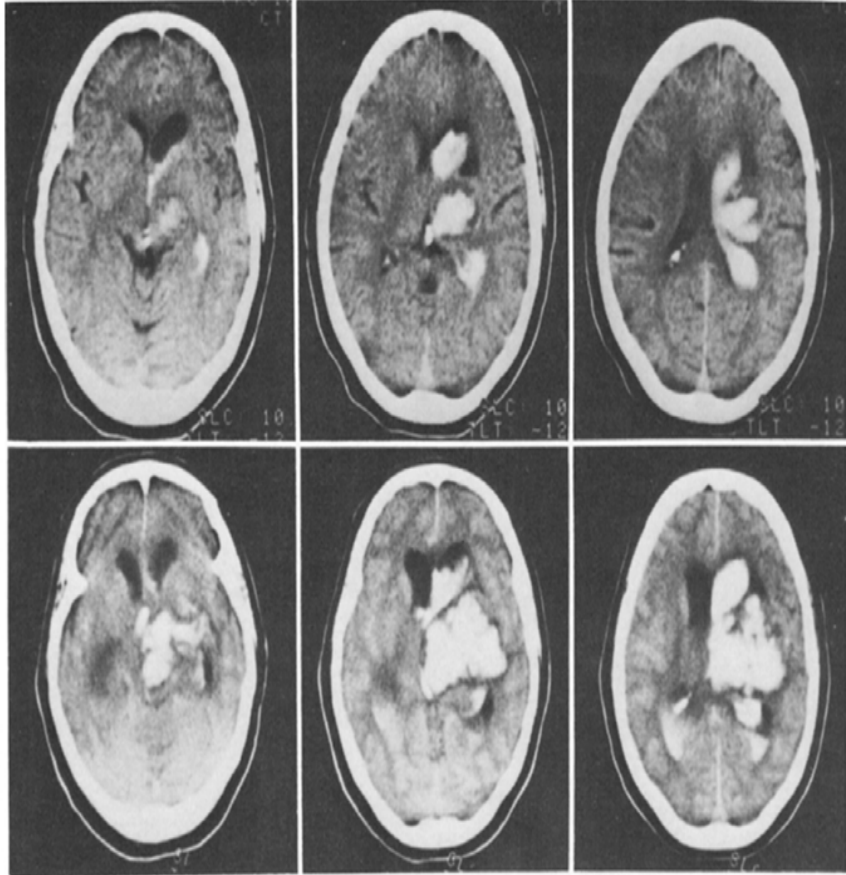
Serial computerized tomography (CT) scans in Case 3. An increase in volume of hemorrhage from 8 to 35 cc was recorded between the first CT scans (*upper*), obtained 50 minutes after onset of symptoms, and the second CT scans (*lower*), obtained 210 minutes after onset.
